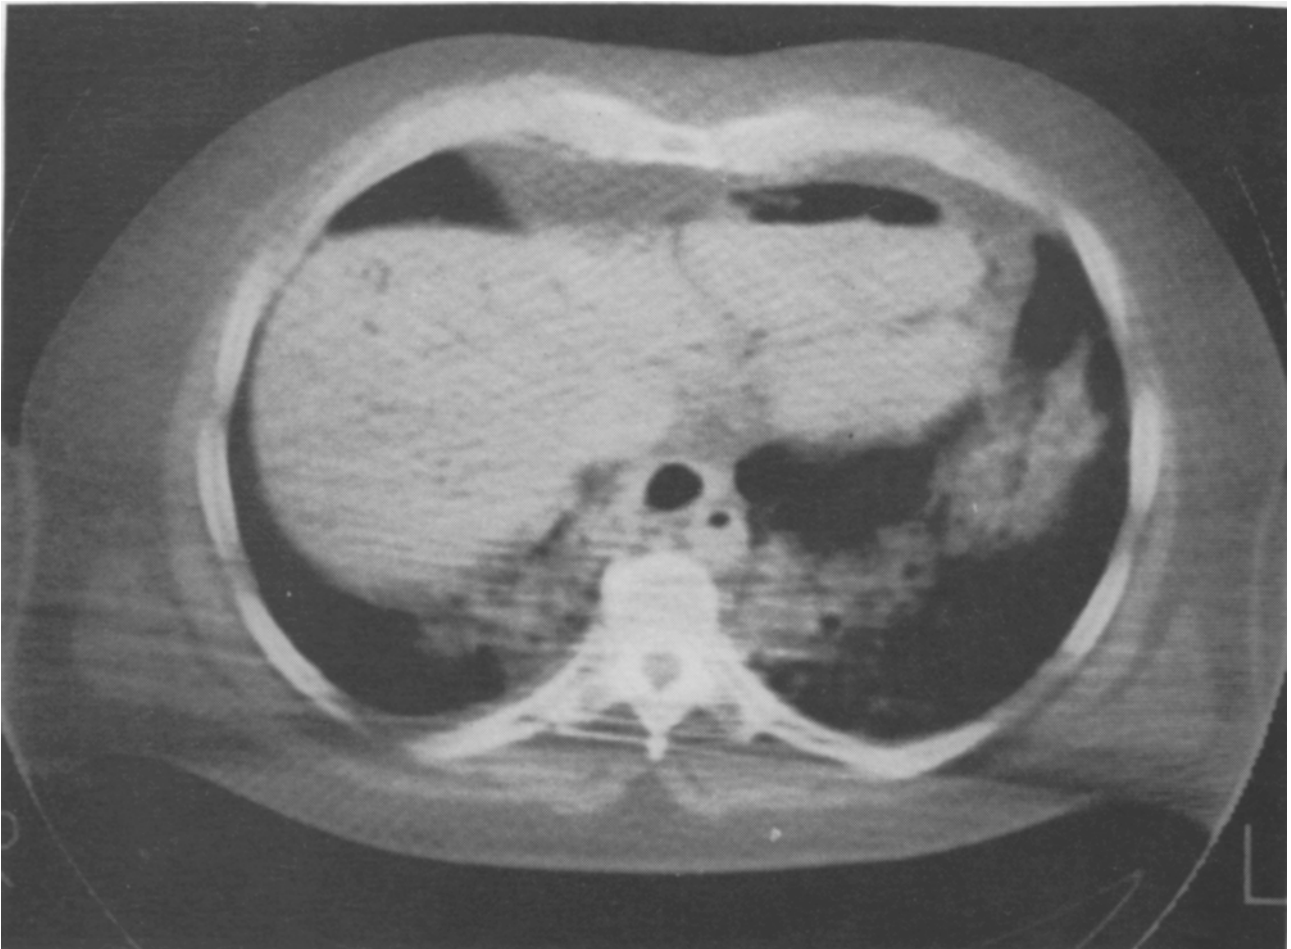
Post mortem CT scan of Case 2. Air can be seen in the left ventricle (black area at the upper right of the picture) and in the thoracic aorta (anterolateral to the vertebral body).
